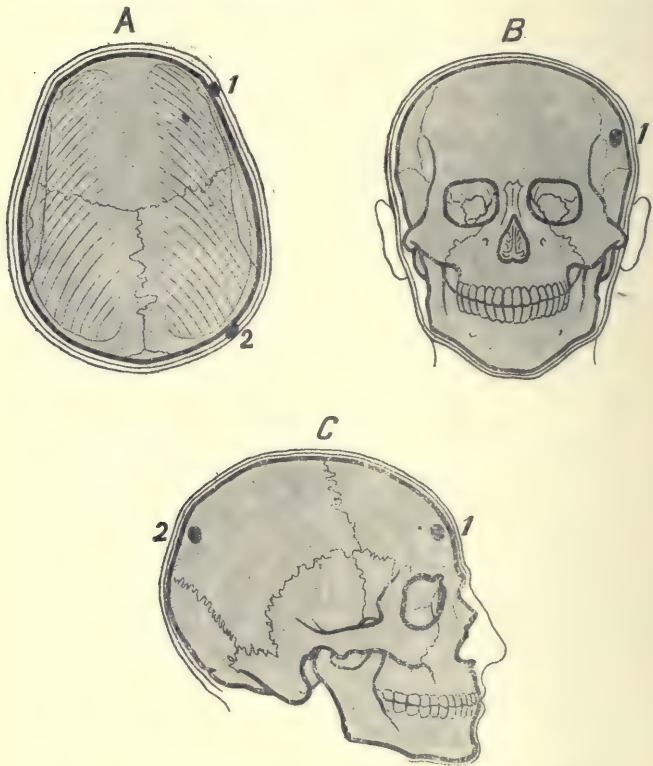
The horizontal section *A* of the skull shows how a projectile situated at 1 or 2 outside the skull, but in the soft parts, will nevertheless cause its shadow to appear to be inside the skull as seen at 1, figure *B*, in a postero-anterior or antero-posterior radiograph. In the lateral view (see figure *C*) these projectiles also appear to be situated in the interior of the skull. In these cases therefore the two radiographs taken at right angles to each other lead to an erroneous conclusion as to the seat of the projectile.
